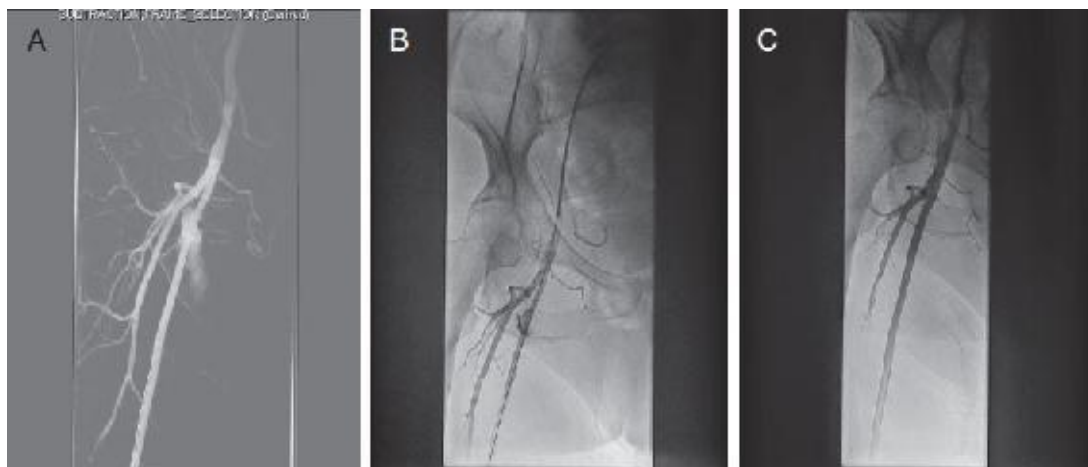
A, Access site bleeding from a sheath that had inadvertently been placed in the pelvis (arrow). Ultrasound guided access above the superficial femoral artery, but in this case, the superficial femoral artery arose above the inguinal ligament. B and C, Right and left common femoral arteries as well as proximal portions of the profunda femoris and superficial femoral arteries.
